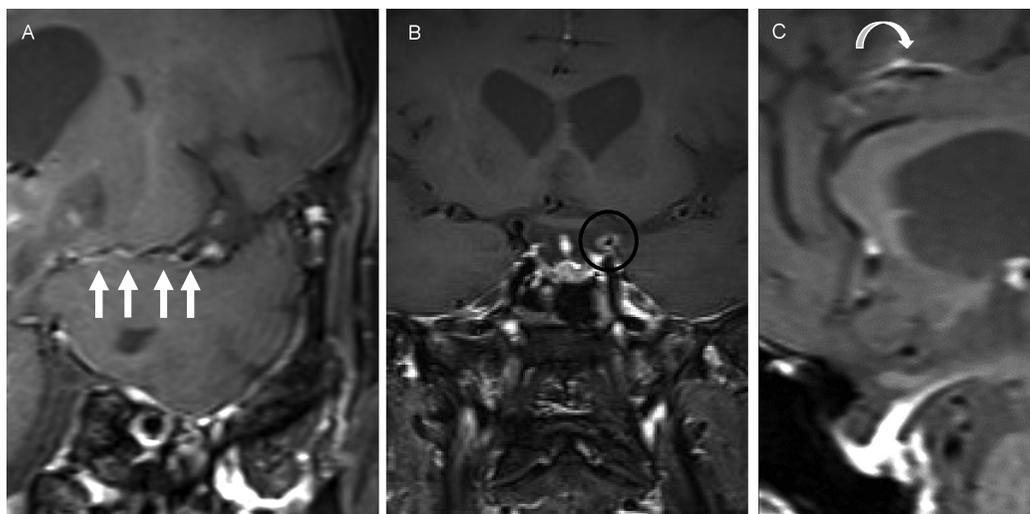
Vessel wall magnetic resonance imaging on the second admission
